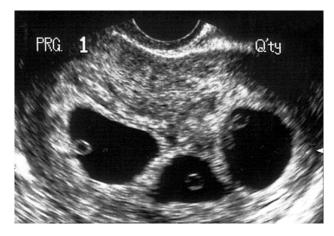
Transvaginal ultrasound scan of triplets at 6 weeks of gestation. There is a high probability for triplets as each gestational sac contains a single yolk sac. However, quadruplets cannot be excluded from this static sonogram
